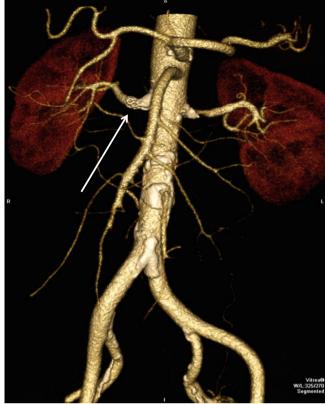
Computed tomography angiography in atherosclerotic renal vascular disease. Reconstructed CT angiogram demonstrating patent left renal artery and patent right-sided renal artery stent (*arrow*)
